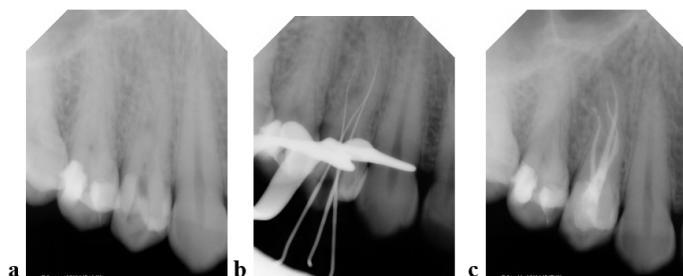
(a) pre-operative radiograph (b) working length radiograph (c) obturation.
